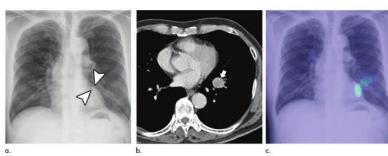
Images in a 64-year-old male patient with a 2.2-cm lung adenocarcinoma at the left upper lobe. (a) The nodule was faintly visible on the chest radiograph (arrowheads) and was detected by seven of 18 observers. (b) Biopsy confirmed lung adenocarcinoma in the left upper lobe on contrast-enhanced CT image (arrow). (c) DLAD reported the nodule with a confidence level of 2, resulting in its detection by an additional two radiologists and an elevated confidence level of the nodule by two radiologists.
